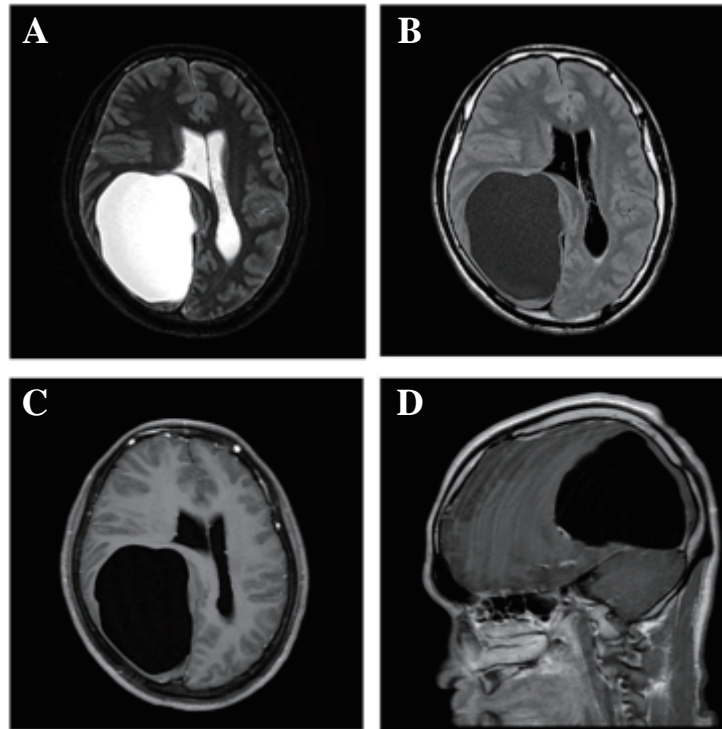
Brain magnetic resonance imaging (1.5T) (A) Axial T2 STIR, (B) Axial T2 FLAIR, (C) T1 with Gadollinium enhanced, (D) Saggital T1 FLAIR showed a huge cystic lesion in right occipital area with uncal and transtentorial herniation.
